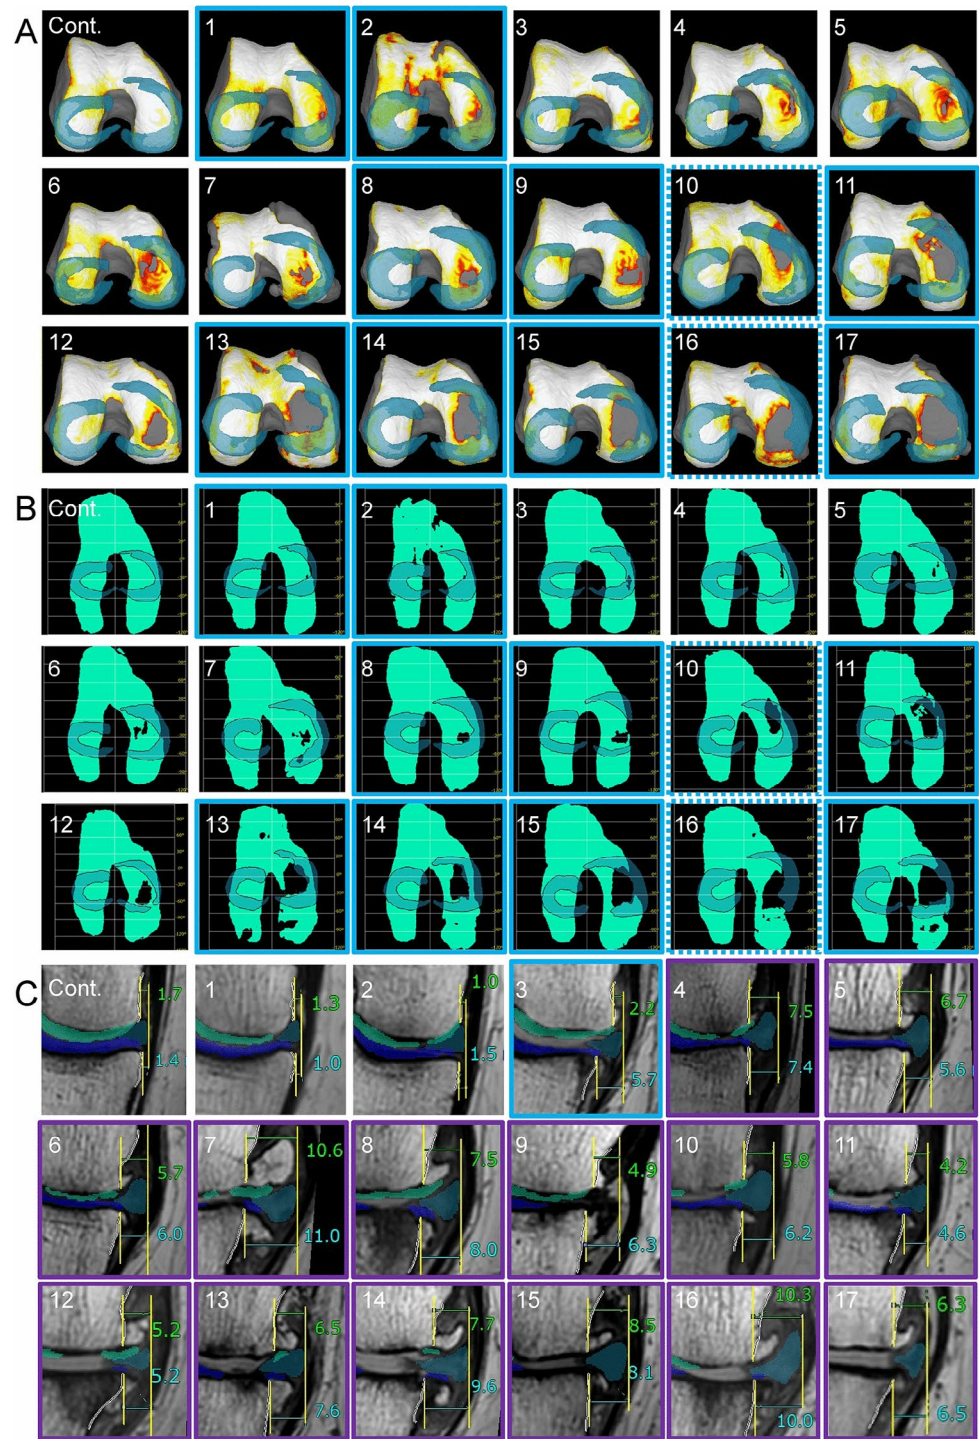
Association between femoral cartilage defects and the medial meniscus. (A) Overlay of vertically projected cartilage thickness mapping of the femoral cartilage and menisci. Blue frames indicate cases where the outline of the cartilage defect touches the inner edge of the medial meniscus. No. 10 shows the cartilage defect outline touching the inner edge of the medial meniscus in a more extended position, while No. 16 shows this in a more flexed position. (B) Overlay of radially projected cartilage area of the femoral cartilage and menisci. (C) Medial meniscus extrusion on 2D MRI. The SPGR coronal image is shown at the level of the maximum tibial width. Femoral cartilage is shown in green, tibial cartilage in dark blue, and the medial meniscus in blue. The width from the inner edge of the femur (excluding osteophytes) to the outer edge of the medial meniscus is indicated by a green number (mm), and the width from the inner edge of the tibia (excluding osteophytes) to the outer edge of the medial meniscus is indicated by a light blue number (mm). The purple frame indicates a meniscus extrusion of 3.0 mm or more for both femur and tibia, and the light blue frame indicates a meniscus extrusion of 3.0 mm or more for the tibia only.
